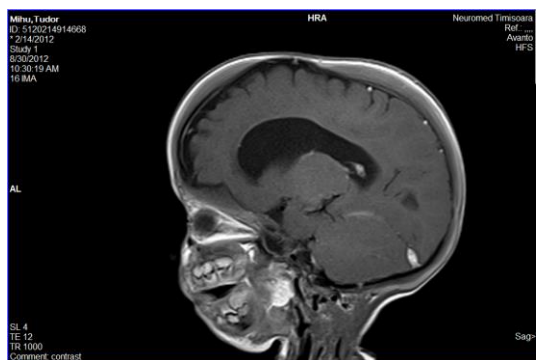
MRI: Hypertrophy of the cranial bones
